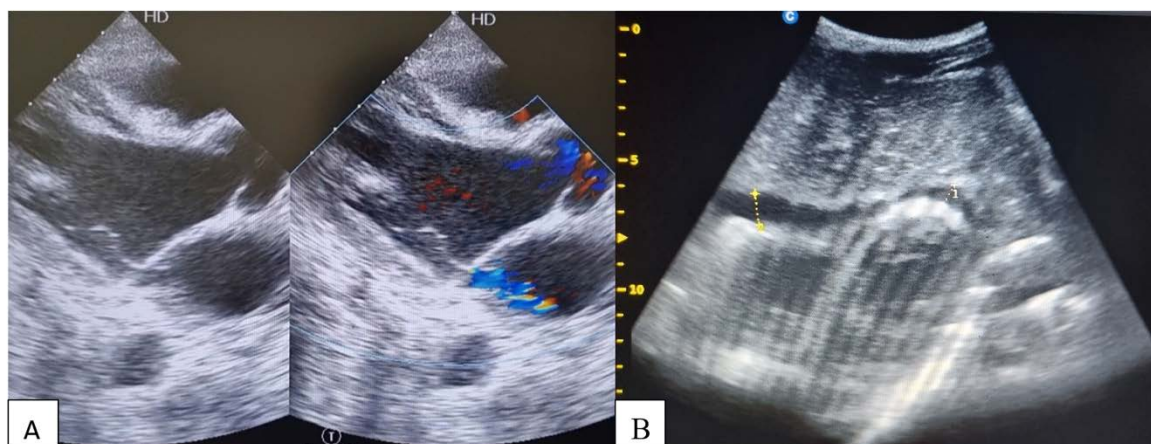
Echocardiography showed A. severely enlarged left ventricle with mitral regurgitation. B. Pericardial effusion
